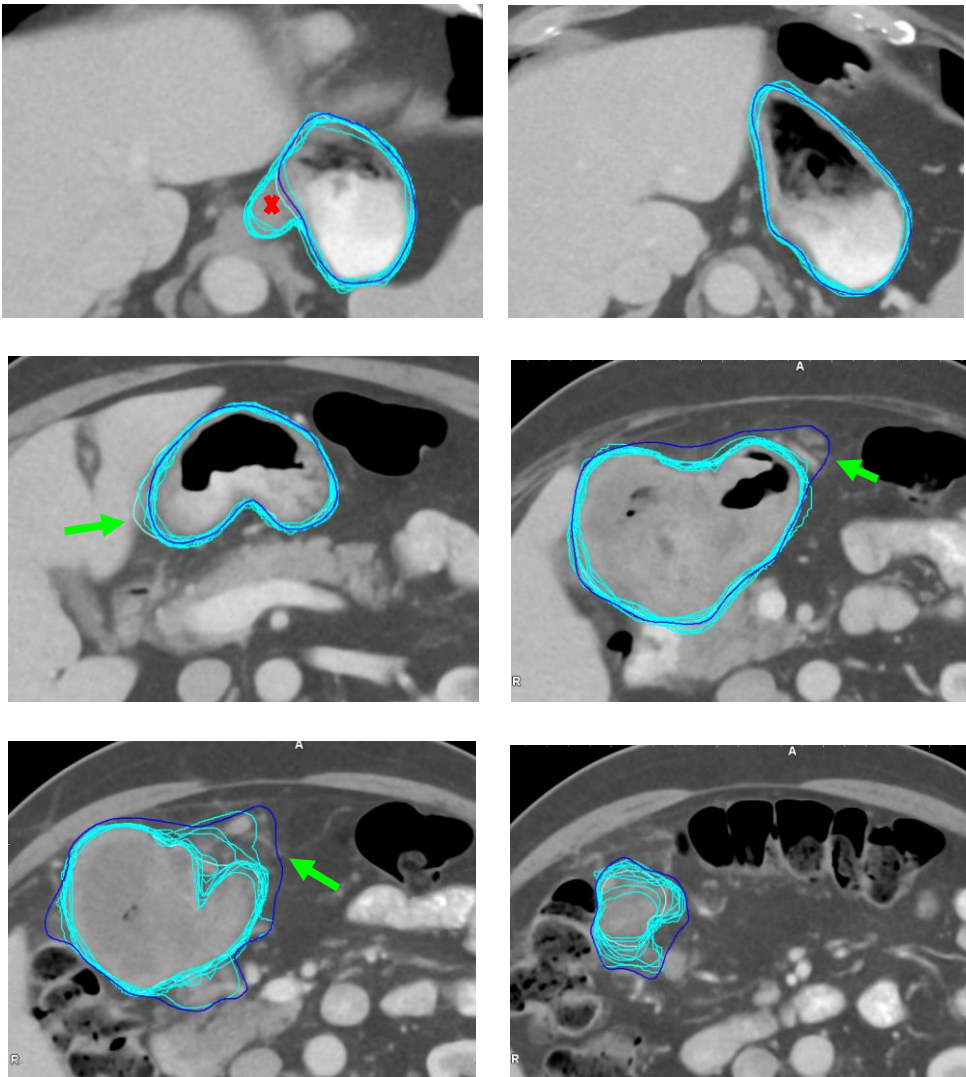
Axial slices of planning CT (selected slices moving L-R from superior top left, to inferior bottom right) demonstrating GTVp\_reference (yellow) and observer GTVp volumes (red) based on phase 2 (CT+MRI) for Case A. The green arrows indicate areas of extra-gastric extension, not encompassed by most observers. The black star shows the lymph node included by 4 observers.
